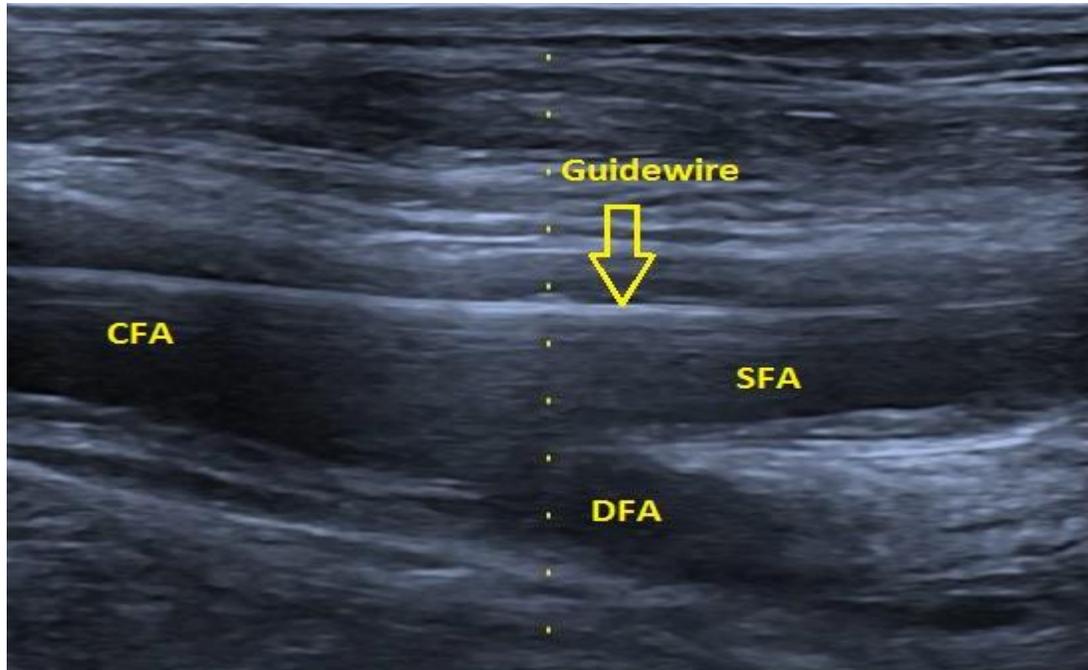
Guidewire passed to SFA under real-time sonography
